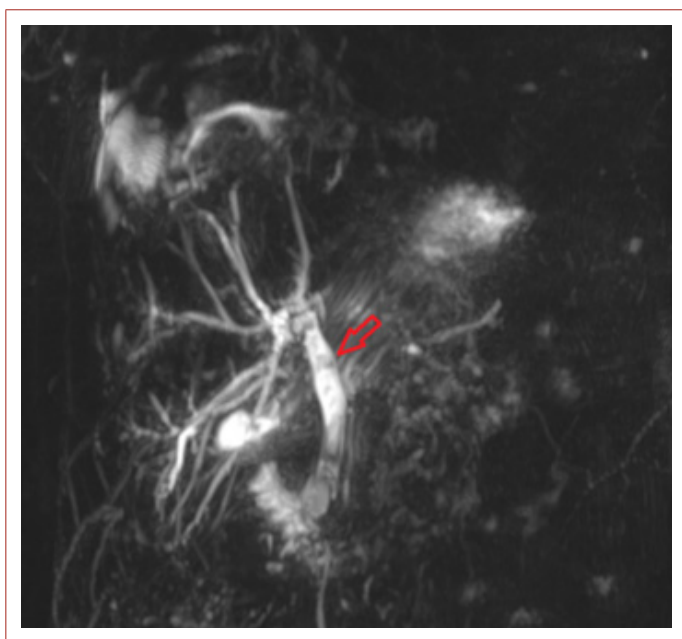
Magnetic resonance imaging showing stones in the patient's bile ducts.
